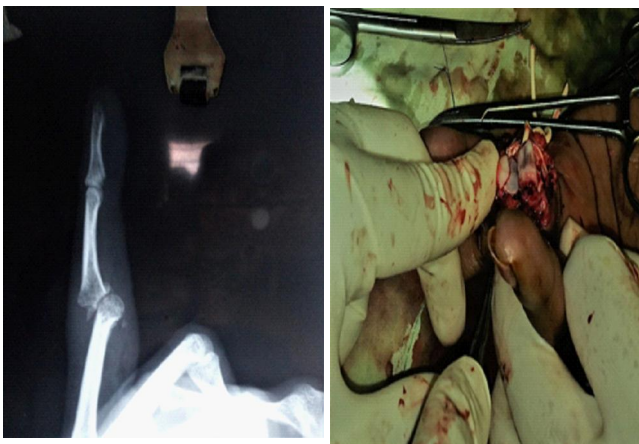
14 showing pre & post op x-ray,Intra op photos& ROM at follow up of Hemi hamate arthroplasty
